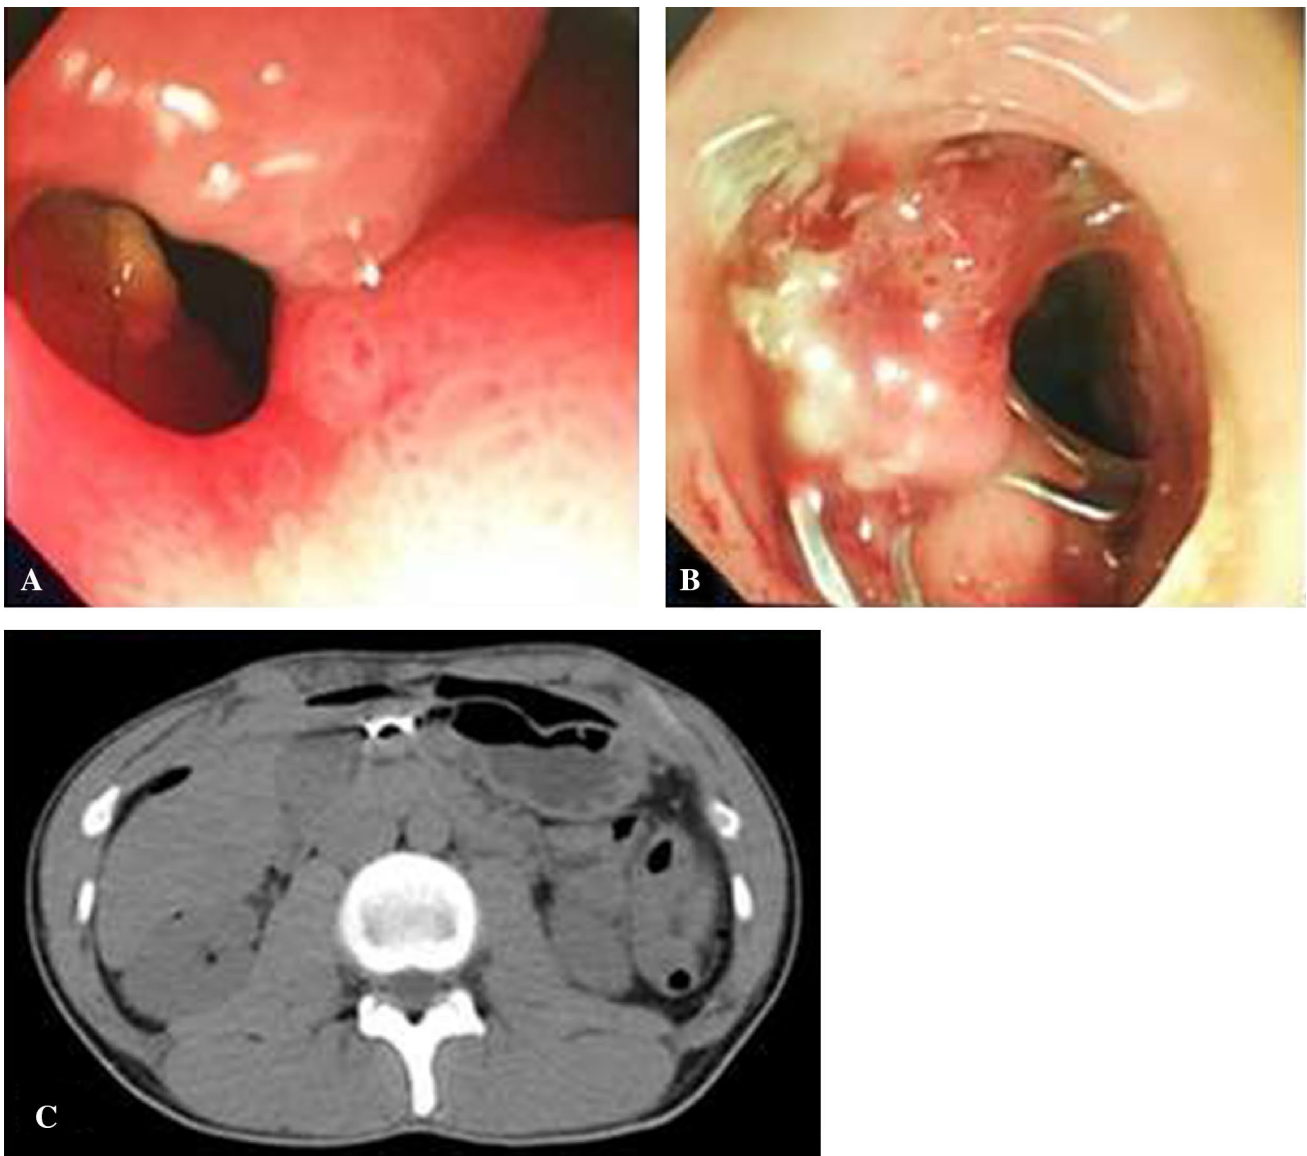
A A perforated peptic ulcer was found in the greater curvature of the duodenal bulb through endoscopic examination; B the perforation was successfully closed by OTSC; C post-operative CT scan revealed the location of OTSC
